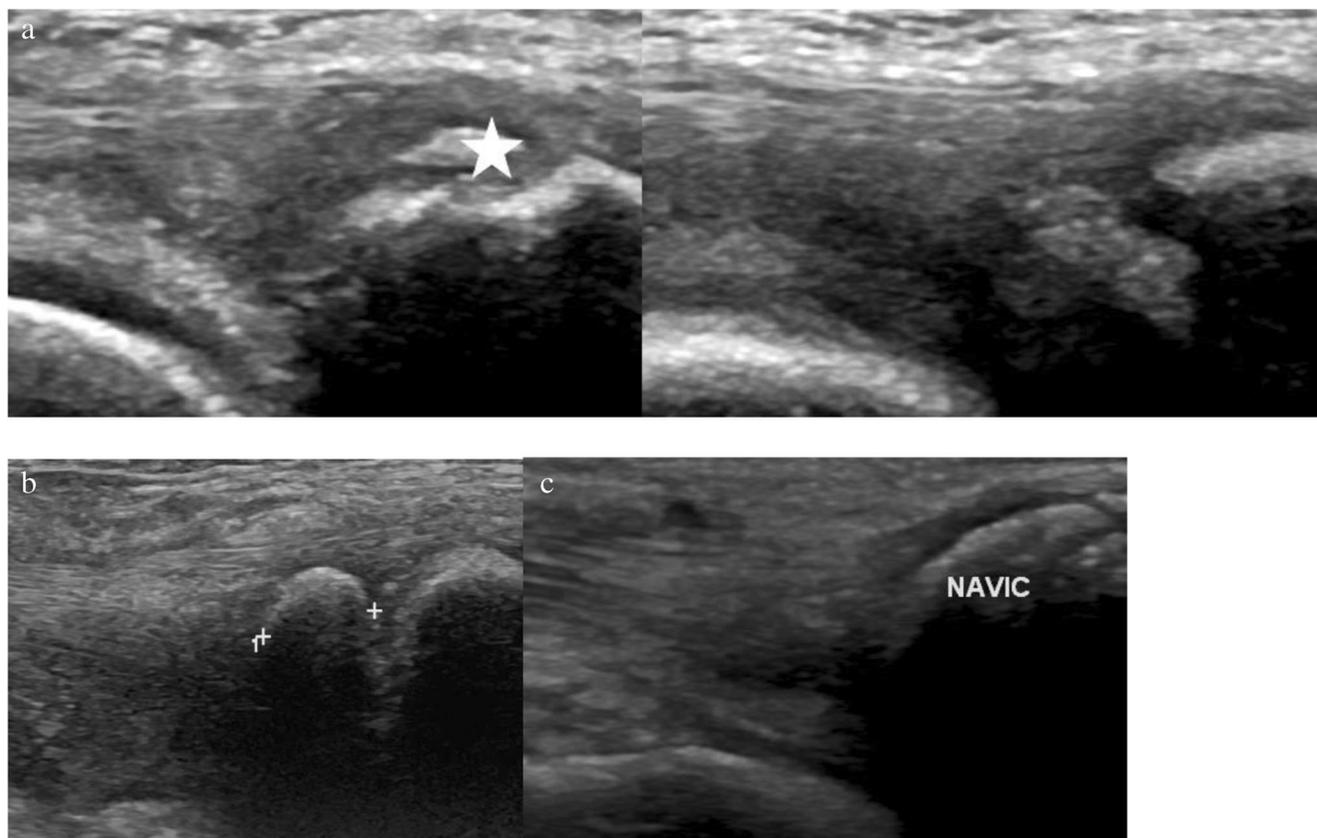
Sonographic images of the normal and accessory navicular types. a Long-axis ultrasound image demonstrates a type I navicular (*star*) within the right PTT, with a contralateral left normal navicular. b Long-axis
